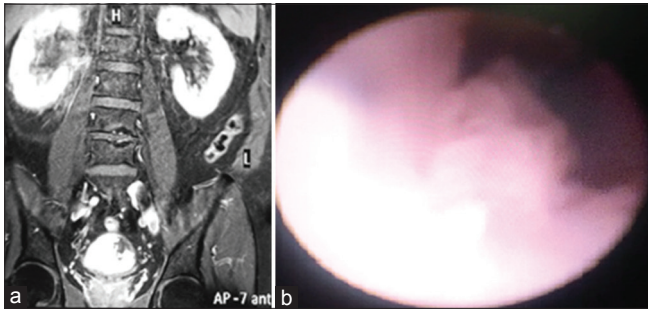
(a) MRI showing a right renal pelvic tumor with bladder tumor (b) ureteroscopy showing a ureteric TCC
